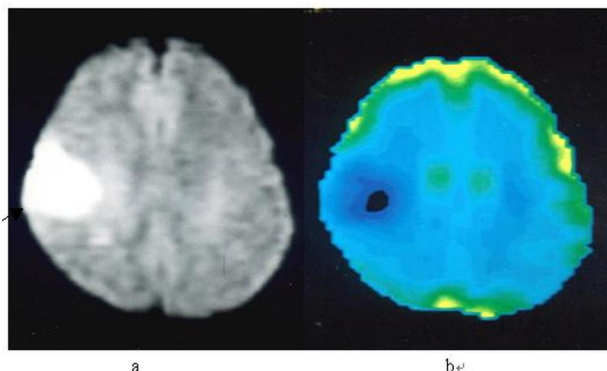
(a) DWI shows early ischemic lesion(arrow) of the right hemisphere 24 hours after the onset of symptom. (b) The corresponding ADC map confirms that ADC reveals gradient sign,the ADC is lower in the lesion core than in peripheral part.
